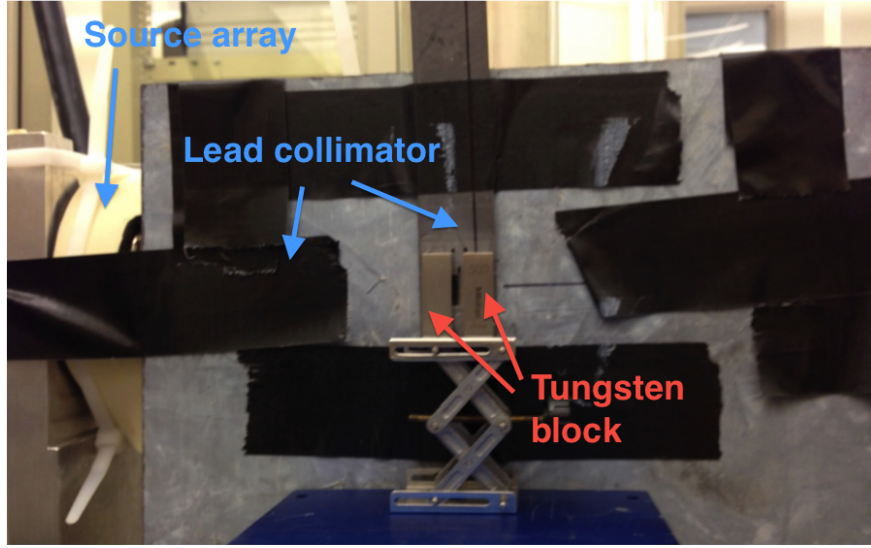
Experimental extra-focal radiation measurement setup. A lead sheet was put in front of the tube window, a square aperture was open to collimate x-ray beams. Two 12.7 mm (0.5 in) thick tungsten block were placed in front of the aperture as extra collimator along x-direction, due to the longer focal spot size in x-direction. The opening between tungsten block was 5 mm.
